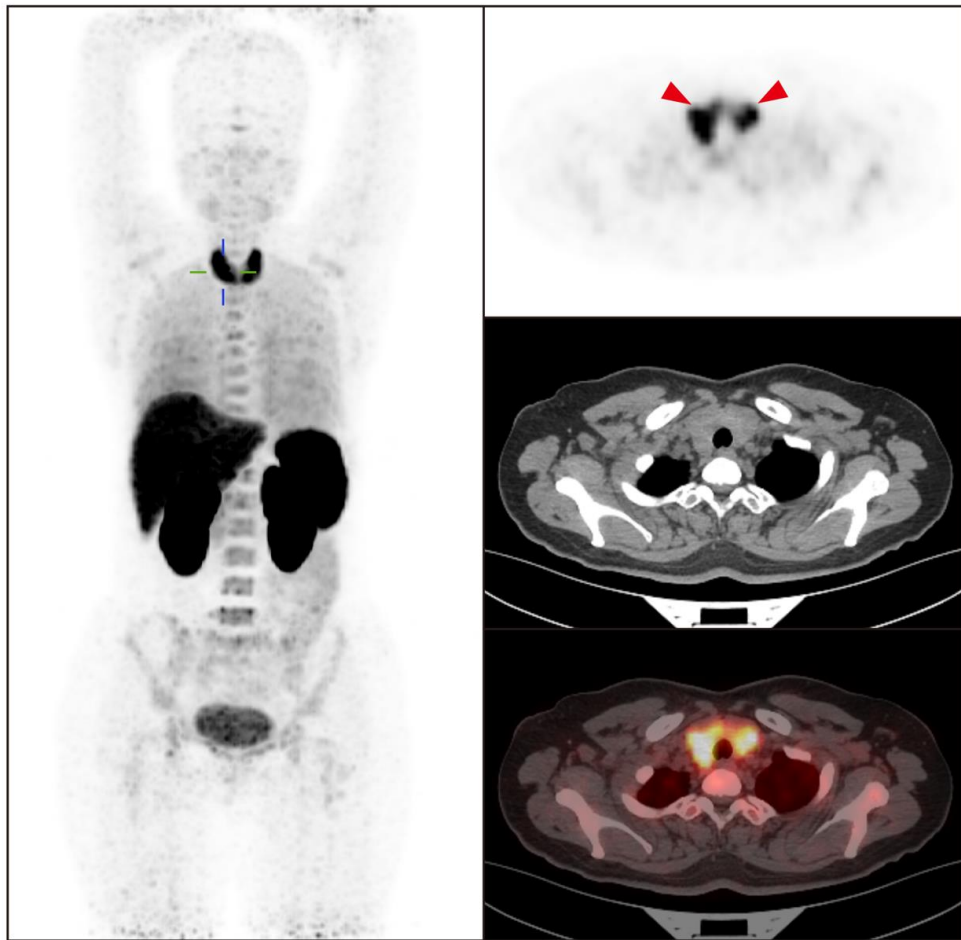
Images of an adult patient with left lower lung adenocarcinoma and thyroiditis (left image: MIP image; Right images from top to bottom: PET image, CT image, and PET/CT fused image).
